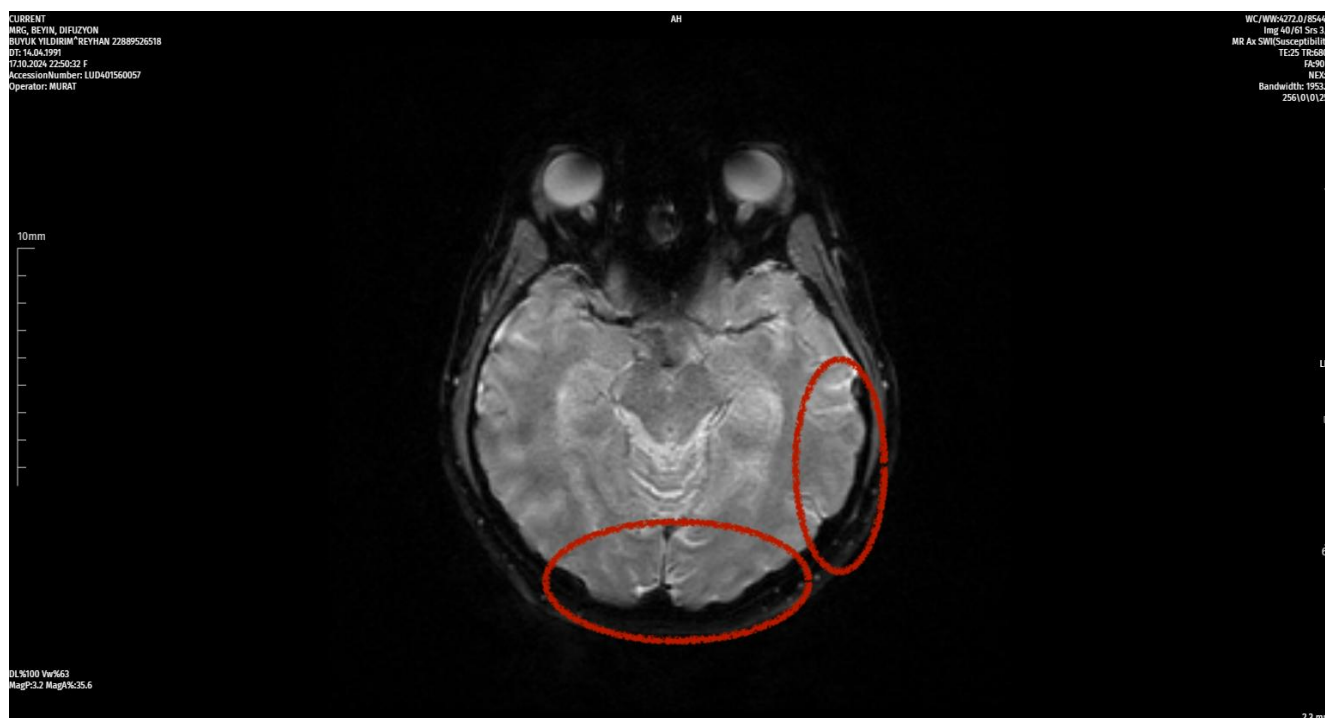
Magnetic resonance imaging (MRI) showed edema in the anterior parieto-occipital region.
